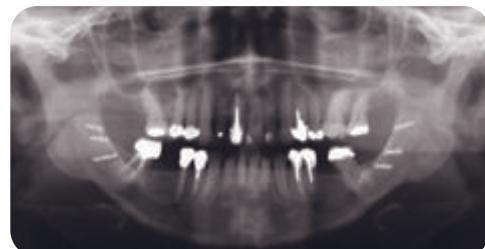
Postorthognathic occlusal photographs and panoramic radiograph.
